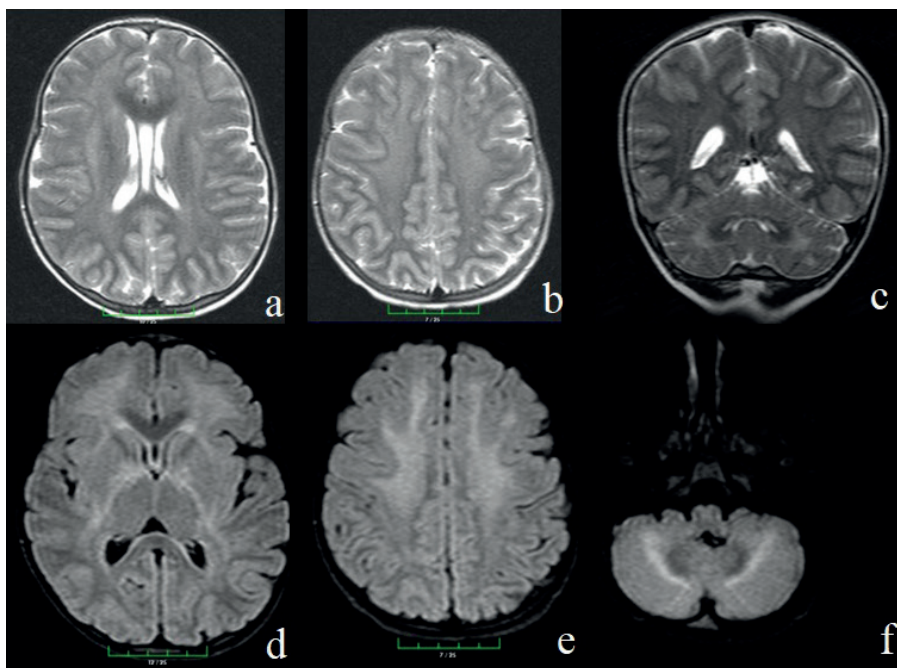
Asymmetric ventricular dilatation (a) in axial T2-FLAIR sections of patient 2 (a, b), especially in posterior localization, hyperintense periventricular (a), subcortical, cerebellar deep white matter areas (b), and hypointense dentate nuclei (a, b).
